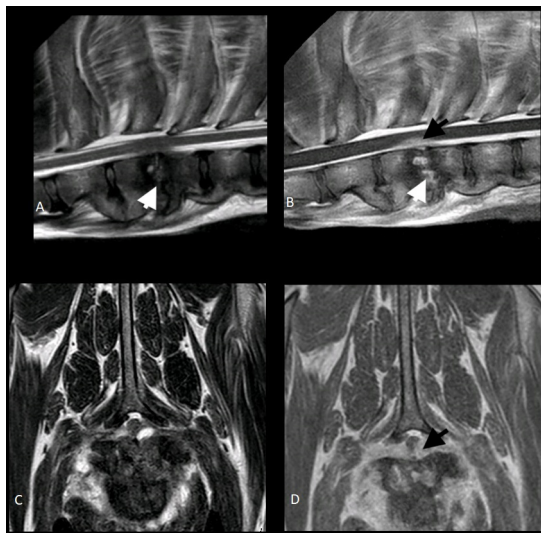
MRI of the thoracic spinal cord of case 12 (after recurrence of clinical signs) demonstrating the T2-weighted hyperintense and contrast-enhancing T2–T3 intervertebral disc (white arrows) consistent with diskospondylitis: (a) sagittal T2-weighted, (b) sagittal T1-weighted postgadolinium, and (c) transverse T2-weighted and (d) transverse T1-weighted postgadolinium. An extradural, mass-like compression that is contrast-enhancing can be observed in ‘b’ and ‘d’ (black arrows), which is consistent with spinal empyema.
